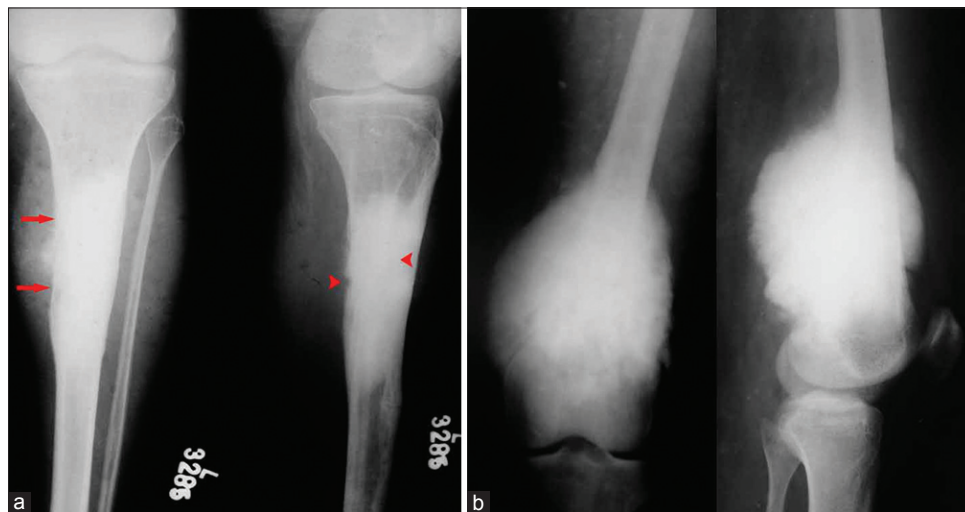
(a) X-ray anteroposterior and lateral views of proximal tibia and knee joint showing diaphyseal osteosarcoma of tibia with sclerosis (arrow), cortical destruction on posteromedial side (arrow heads) and new bone formation in the soft tissues (b) x-ray distal end of femur (anteroposterior and lateral views) showing sclerosis/radio-opacity in sclerosing osteosarcoma
